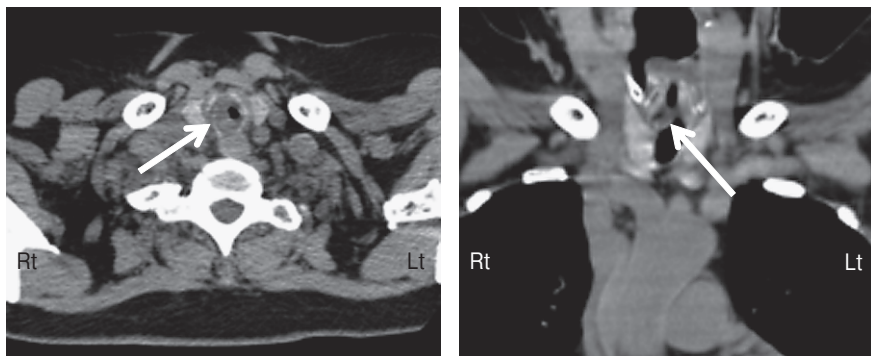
Computed tomography reveals stenosis of the entire circumference of the trachea over a length of 1.0cm. Left, axial; right, coronal.
